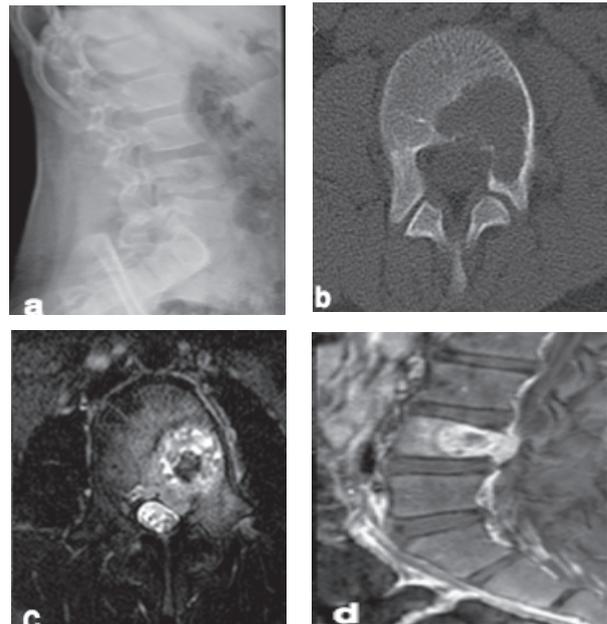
(a) CT Showing a Well-Defined Lytic Lesion at L4 Extending to the LT Pedicle and Focally Violating the Posterior Vertebral Wall (b) MRI Showing Multiple Small Fluid-Fluid Level with Soft Tissue Component and Mild Extension into the Epidural Space (c) Vertebral Compression Posteriorly (d) Post Contrast Enhancement
